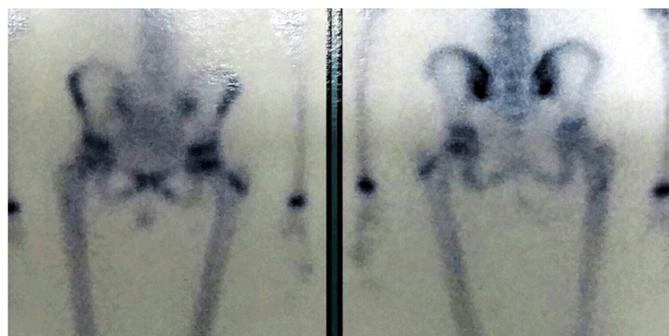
Both views of technetium scintigraphy, confirming the absence of osteonecrosis of the femoral head.
